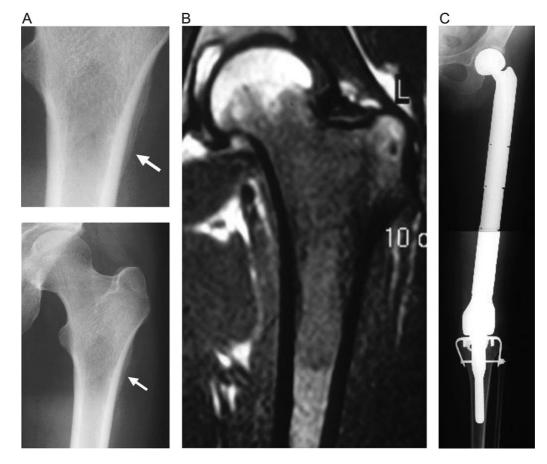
Ewing's sarcoma of the femur. (A) Plain roentgenogram displays a permeative lesion of the proximal femoral shaft associated with an 'onion skin' periosteal reaction (*Arrow*). *Insert* is a magnification of 'onion skin' periosteal reaction (*Arrow*). (B) A coronal T1-weighted MR image displays a low-signal intramedullary tumor involving the long segment of the femoral shaft that extends into the femoral neck. Note that the involvement detected by MRI extends beyond the anticipated area seen on plain roentgenogram. (C) After resection with wide margins, the affected limb was reconstructed with endoprosthesis.
